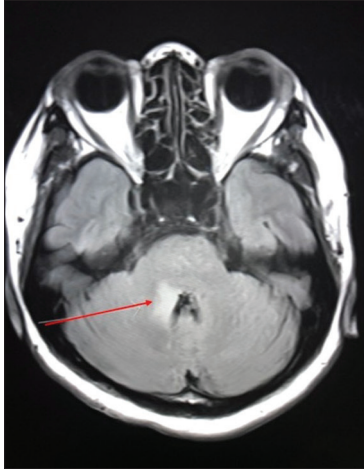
Postoperative magnetic resonance imaging four months after the first surgery showing a small infiltrative residual tumor (red arrow).
